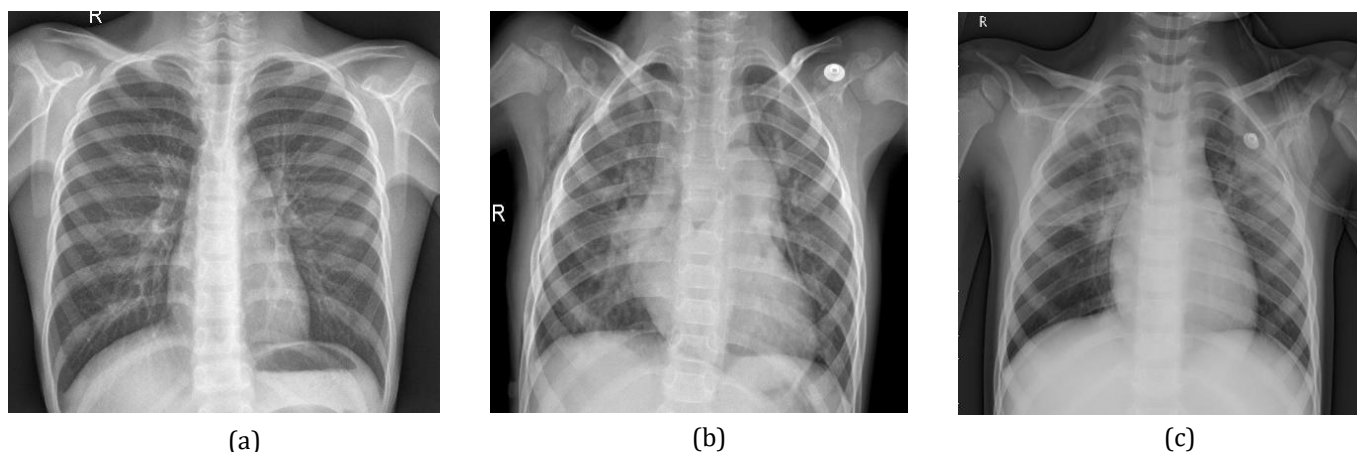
Radiographs from Kermany Dataset (a) Radiograph of a patient with healthy lungs (b) Radiograph of a bacterial pneumonia affected patient (c) Radiograph of a viral pneumonia affected patient.
